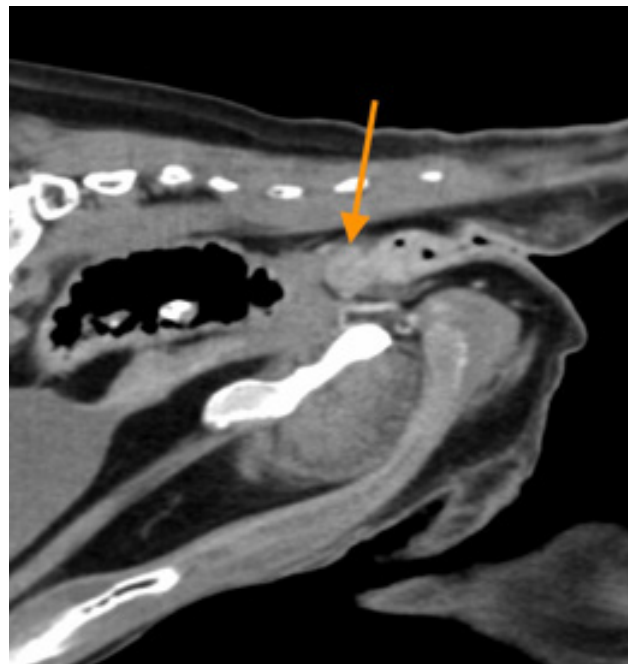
Sagittal computed tomography projection demonstrating anal gland sac mass (orange arrow)
